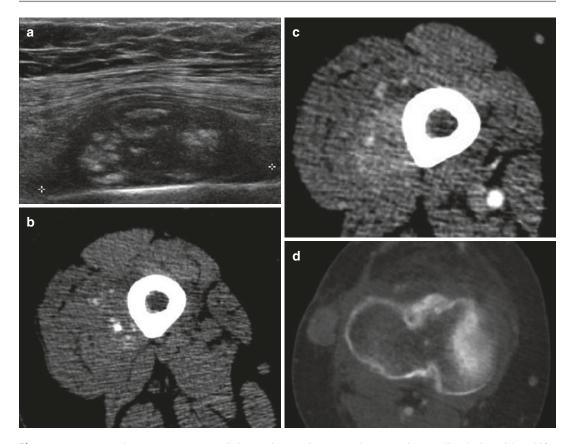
Intramuscular metastases. (a) US image in patient with previously diagnosed osteosarcoma: well-defined hypoechoic mass with multifocal hyperechoic areas located within the vastus intermedius. (b) Nonenhanced and (c) contrast-enhanced CT demonstrates
